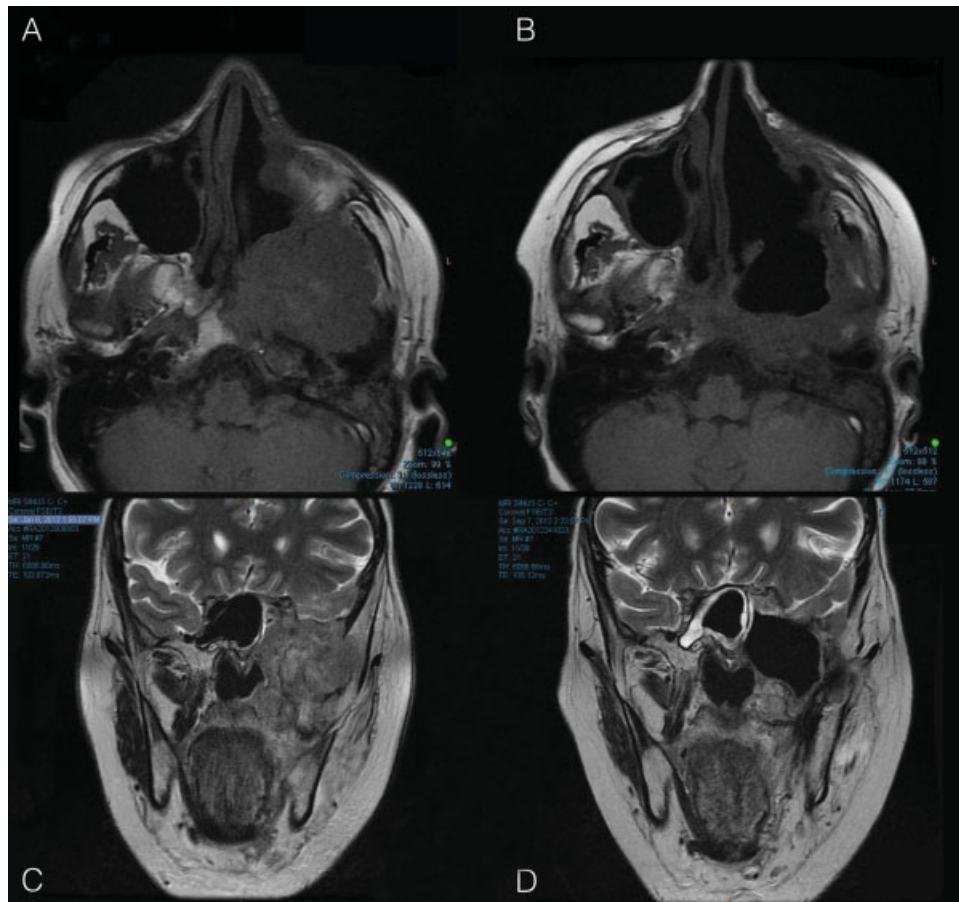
Magnetic resonance Imaging of the sinuses (A) April 2012 axial, (B) September 2012 axial, (C) April 2012 coronal, (D) September 2012 coronal. Pre- and post-hydroxyurea demonstrating a significant objective radiologic response.
